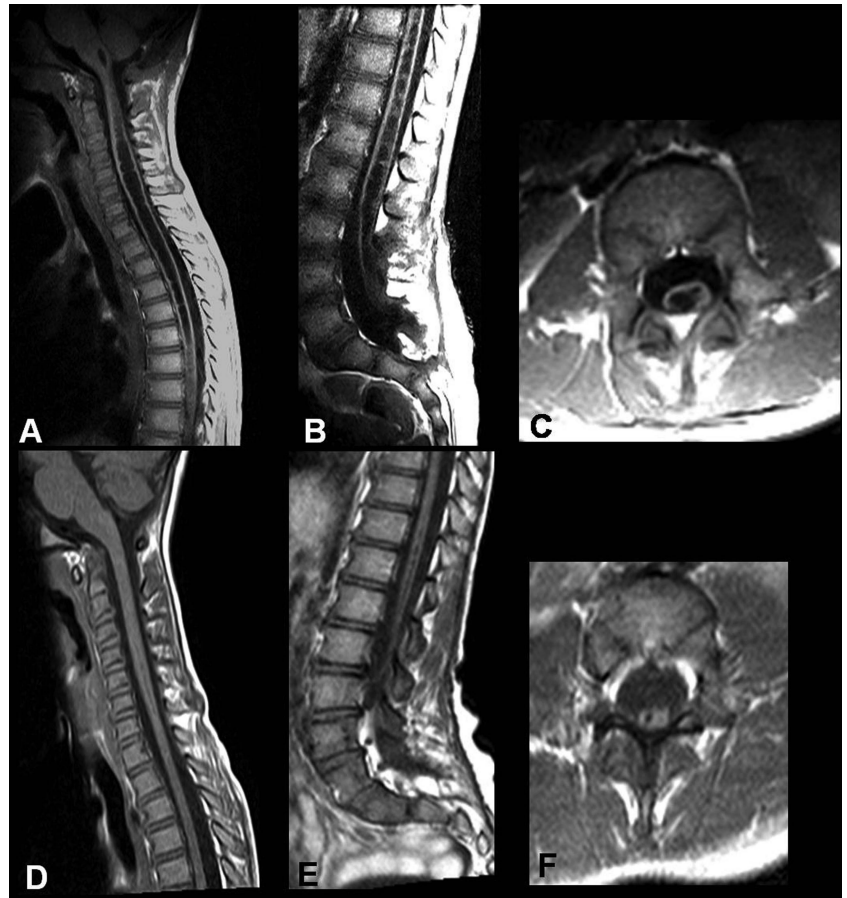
A, B, C, Preoperative sagittal and axial T1-weighted MRI scan demonstrating a syringomyelia and hydromyelia holocord and the enlargement of the ependymal channel greater than the 50% of the spinal cord's diameter. D, E, F, Postoperative follow-up MRI images showing a reduction in syrinx size.
